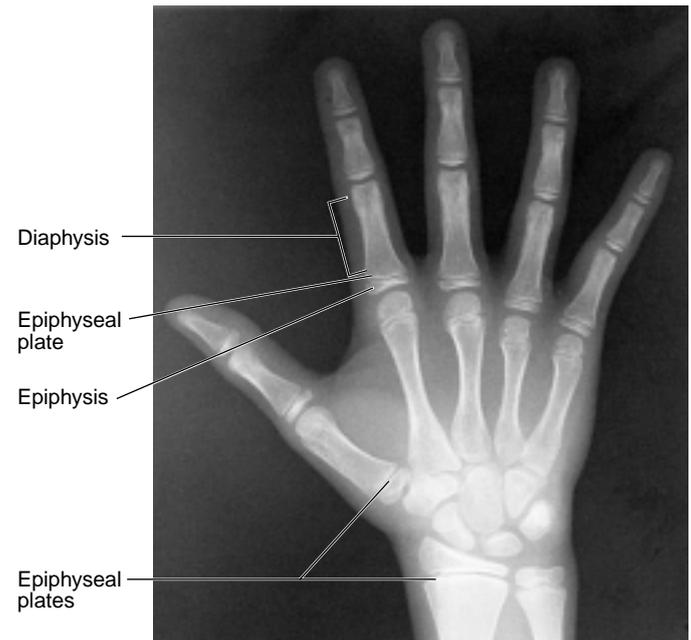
The presence of epiphyseal plates as seen in a radiograph of a child's hand. The plates indicate that the bones are still growing in length.
